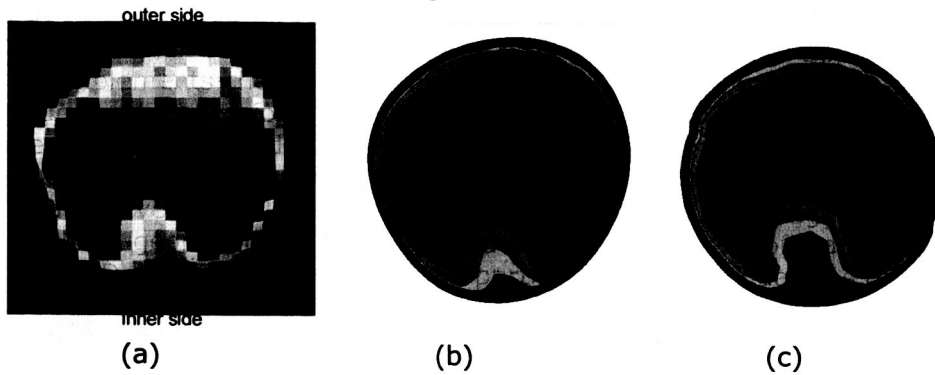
Through-plane velocity at the top of the arch: (a) MRI velocity data; (b) Image-based CFD data; (c) Idealized-geometry CFD data
